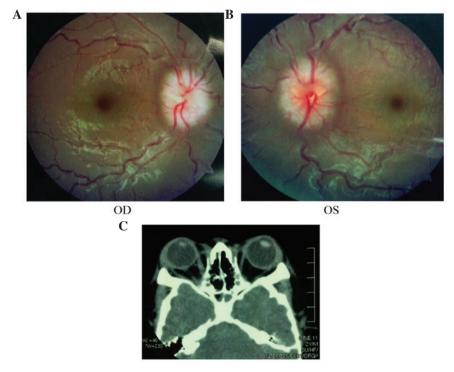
Images of the examination of the proband of family 2. (A and B) Papilloedema of both eyes were noted. (C) Shallow orbits were found on Computed Tomography examination. OD, right eye; OS, left eye.
